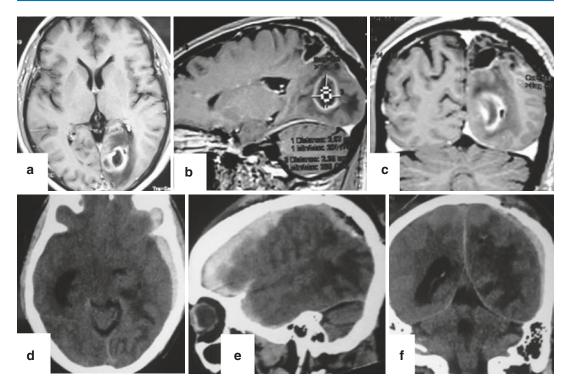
Contrast MRI of the brain; (a) axial images, (b) sagittal images, and (c) coronal images showing left parieto-occipital TBA, recurred after surgical removal of parietal tuberculoma. CT scan of the brain after removal
